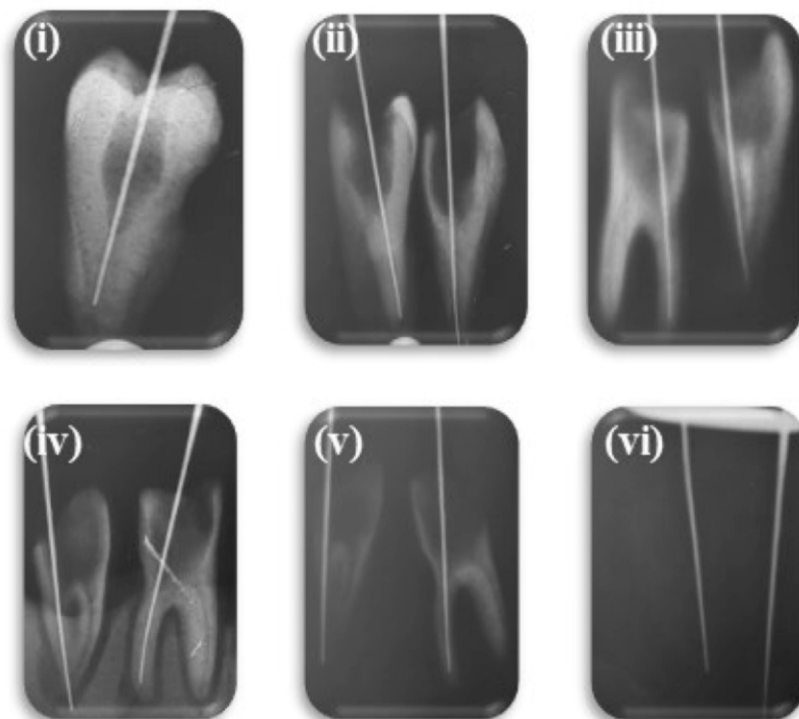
Radiographs taken to assess the process of demineralization post nitric acid (HNO<sub>3</sub>) decalcification after 24 hrs each. i) Before Nitric Acid treatment at (0 hours) ii) At 24 hours iii) At 48 hours iv) At 72 hours v) At 96 hours vi) At 120 hours
